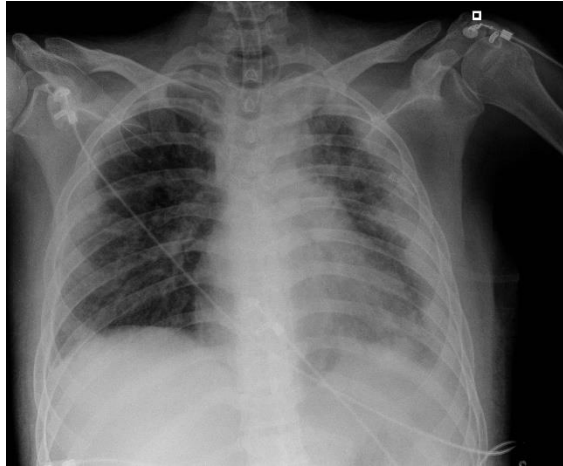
Overinflated ETT cuff seen on chest X-ray of the third patient.
